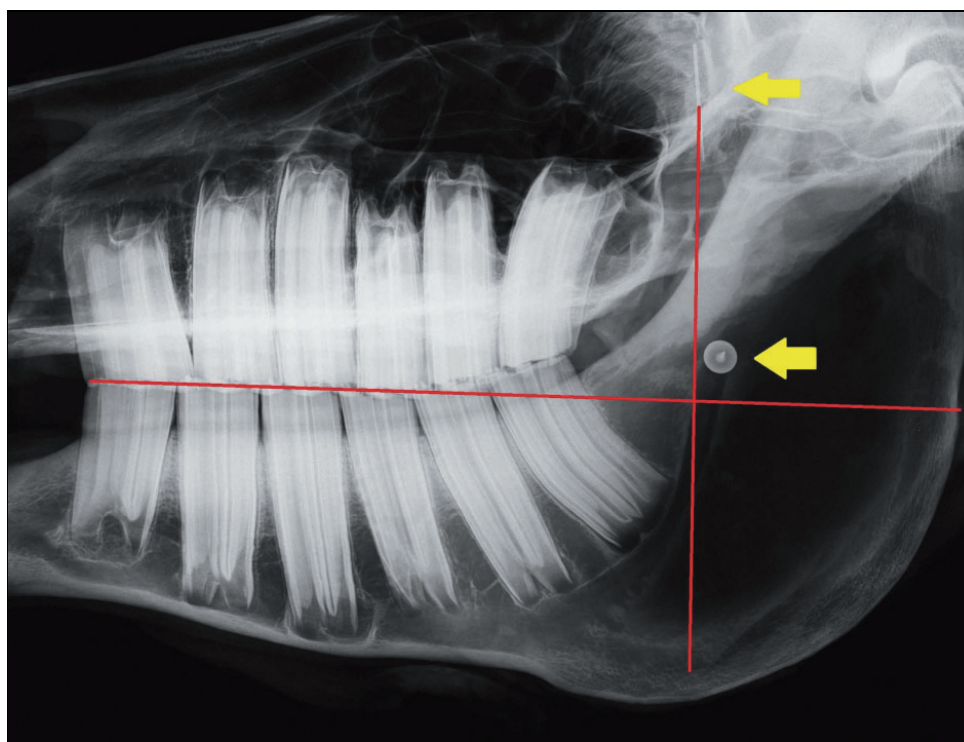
Radiograph of a hemi-mandible showing the 2 imaginary lines pointing out the location of the mandibular foramen. Lower yellow arrow shows aiming target area<sup>6</sup>.
